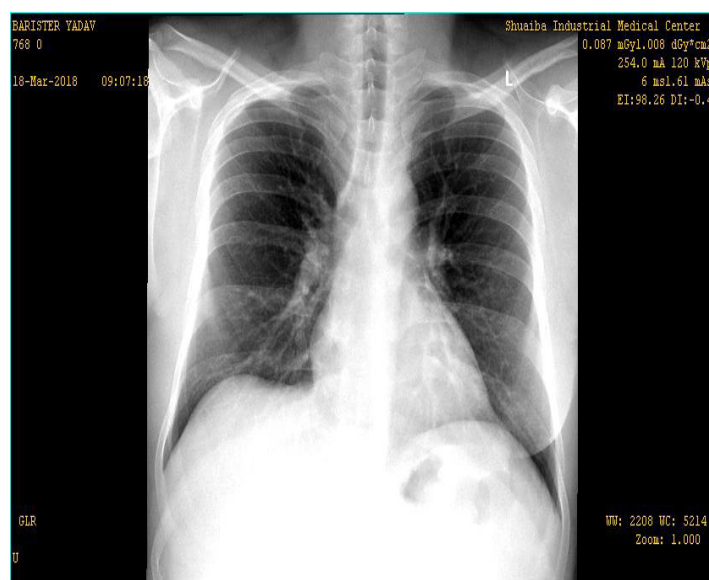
Plain chest x-rays postero-anterior view shows bilateral macro and micronodular infiltration (1/1 profusion grade, size t) with minor atelectasis in right middle lobe.
